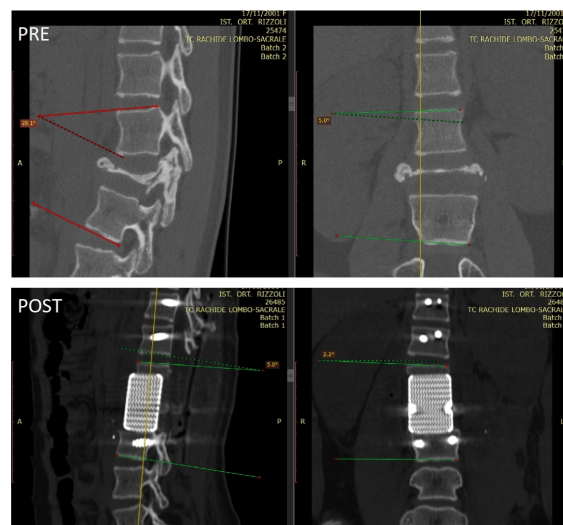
CT images cobb angle pre and post surgery with carbon cage [28, 29]
